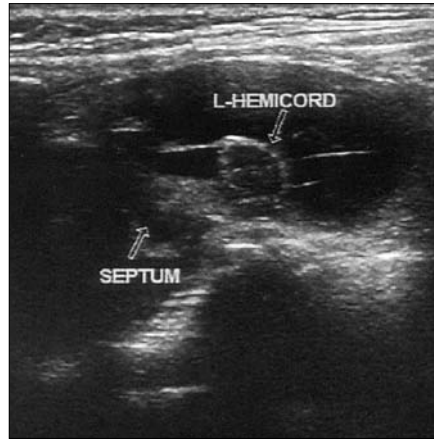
Transverse ultrasonographic image shows a bony spur (septum) between the two hemicords.
